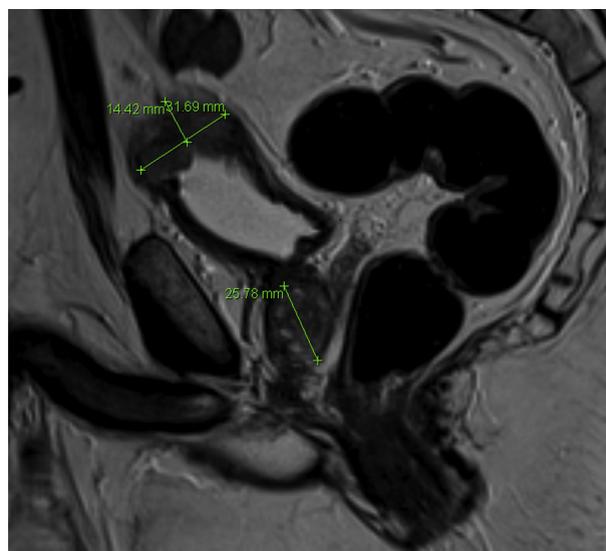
Sagittal T2-weighted magnetic resonance image demonstrating a PIRADS 5 prostate lesion and a T3b superior bladder lesion.
